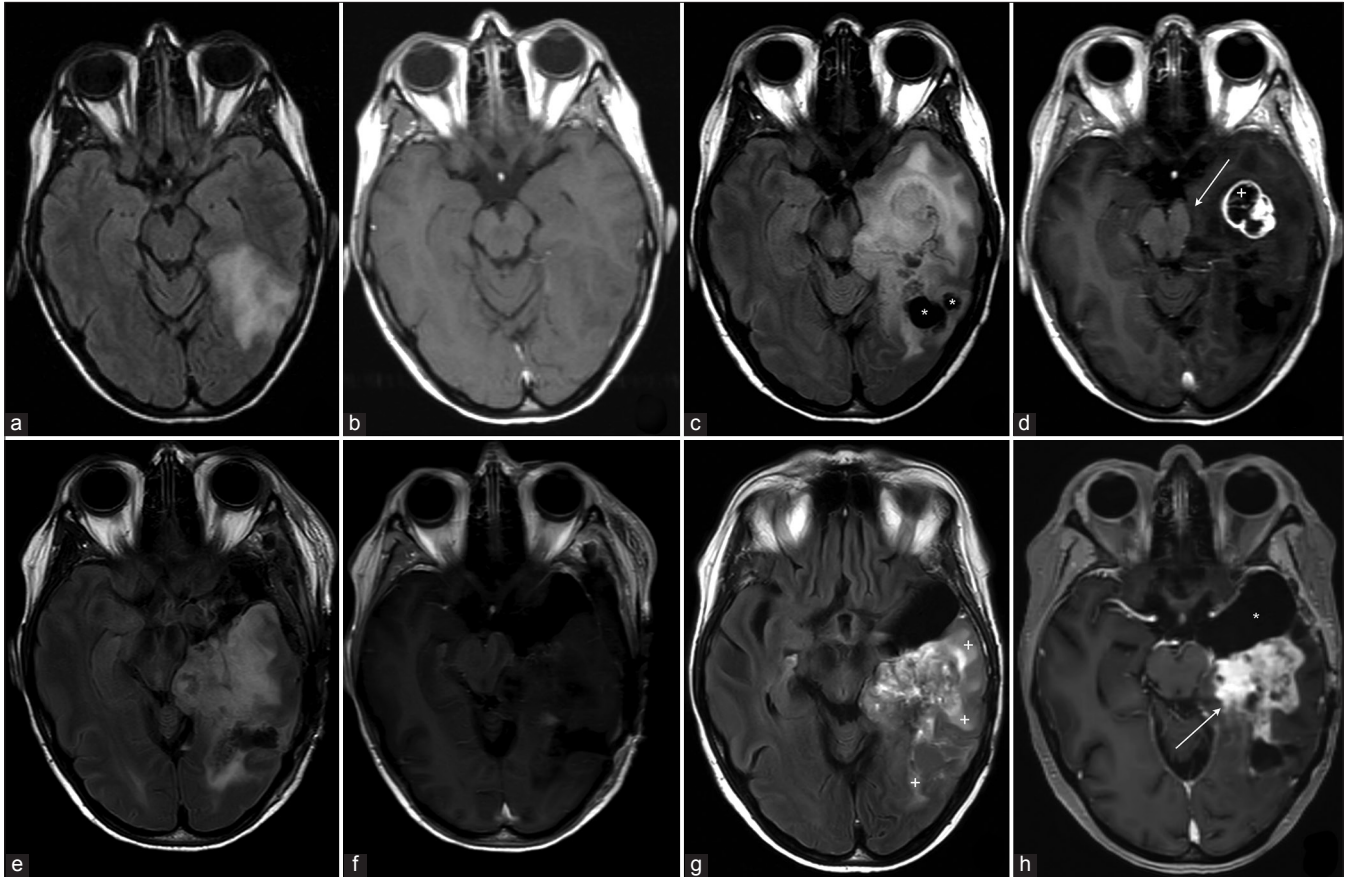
(a) Transverse FLAIR and (b) contrast-enhanced T1 at presentation show a non-enhancing T2-hyperintense mass in the left temporal lobe. These findings favor a low-grade tumor but are otherwise non-specific. (c) Transverse FLAIR and (d) contrast-enhanced T1 10 years after first presentation. There is evident progression of the mass, with cystic components (*) and a rim-enhancing component (+) in the anterior temporal lobe. Increase of transtentorial herniation with mass-effect on the brainstem (arrow). (e) Transverse Flair and (f) Contrast enhanced T1 Postoperative within 72 h shows slight residual pathological contrast enhancement at the resection margins, suggesting minimal rest tumor. (g) Transverse FLAIR and (h) contrast enhanced T1 13 years after first presentation. Despite anterior debulking (*marks the postoperative defect), there is evident progression of enhancing tumor (arrow) and surrounding edema (+).
